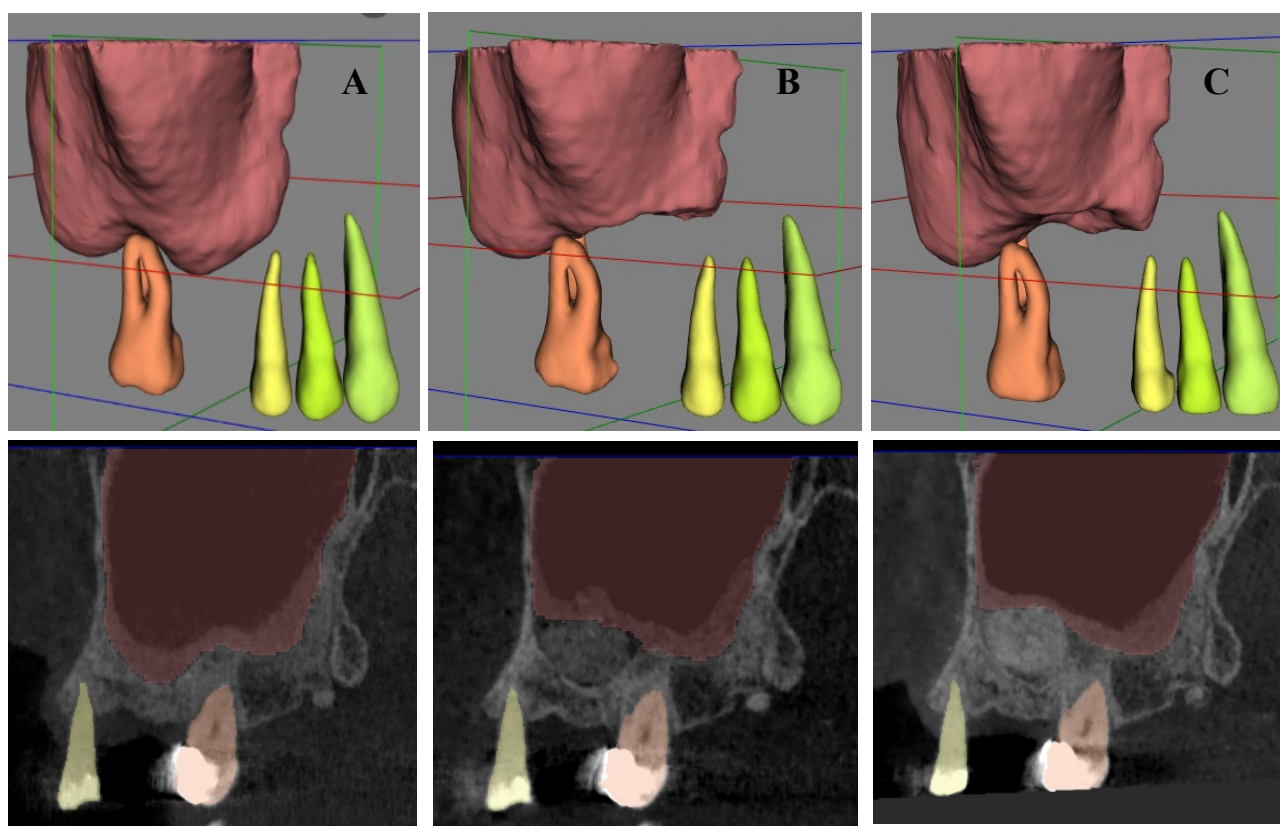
Automated segmentation of maxillary sinus on cone-beam computed tomographic images. A. preoperative image, B. immediate postoperative image, C. 6 months postoperative image.
